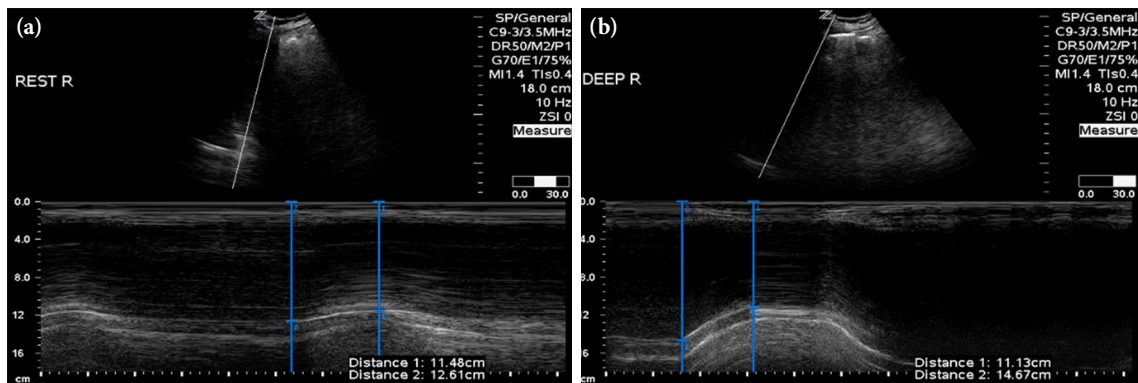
M-mode ultrasonography demonstrating improved right hemidiaphragm excursion during tidal volume (a) and deep (b) breathing six months post-trauma.
